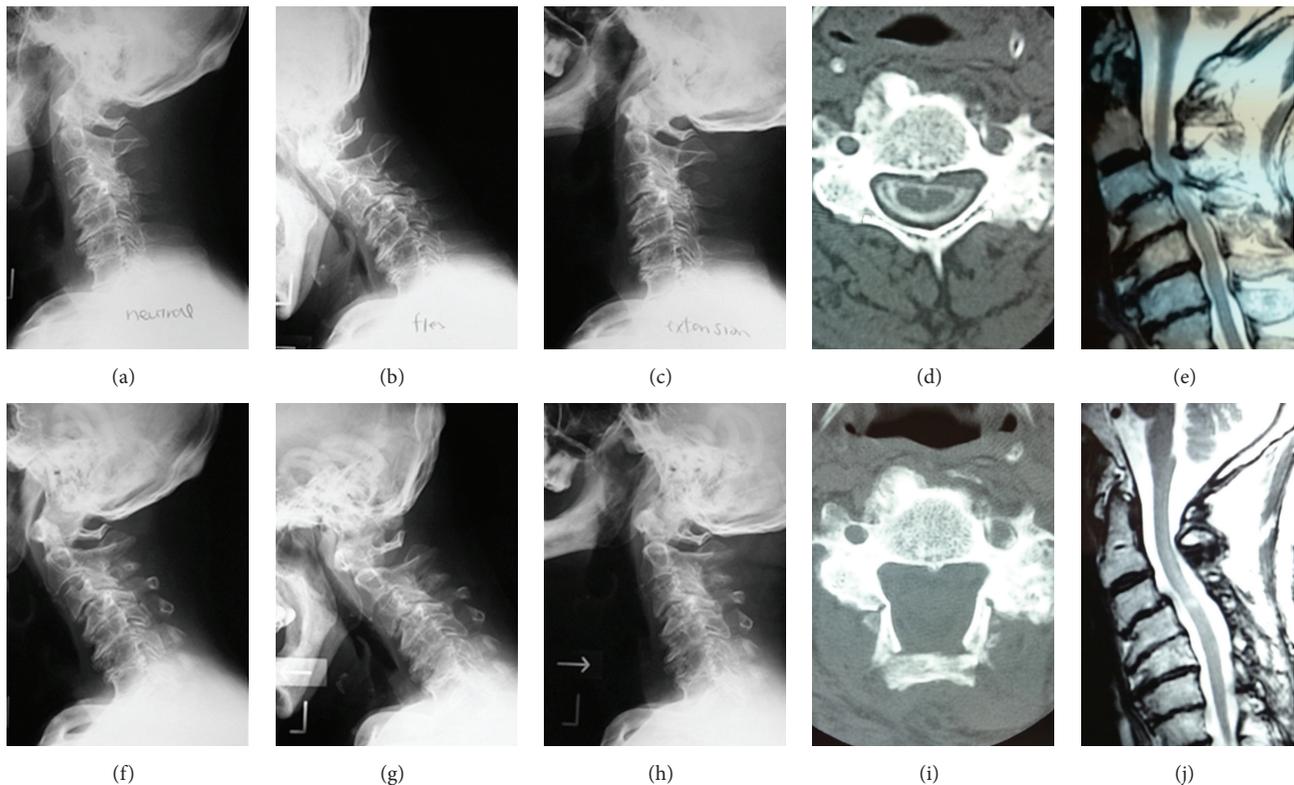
A 76-year-old man who underwent C3–7 laminoplasty for cervical spondylotic myelopathy. Pre- (a–e) and postoperative (f–j) radiographs, CT, and MRI images are shown. Pre/postoperative C2/7 Cobb angles and range of motion were 0/–7 and 33/25 degrees, respectively. Although slight kyphosis progressed after surgery, the patient underwent a good clinical course. Pre- and postoperative (96 months) JOA scores were 9 and 11, respectively.
